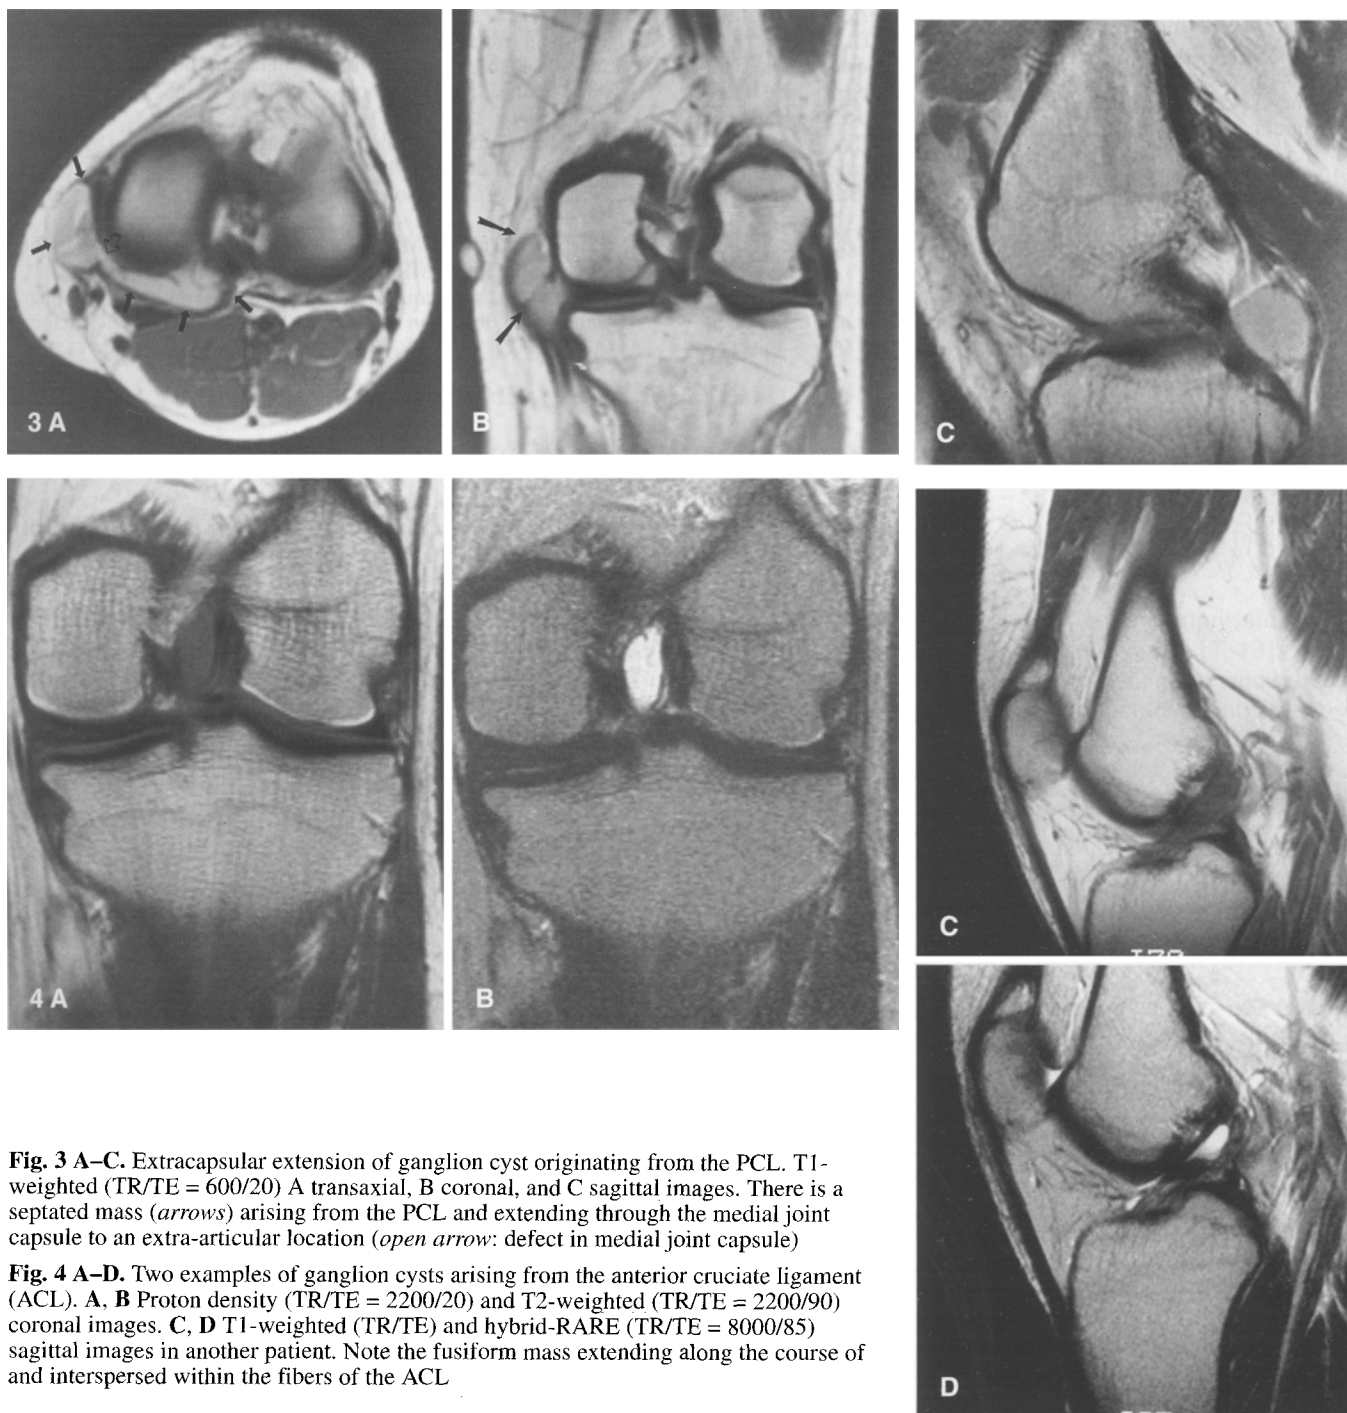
A-C. Extracapsular extension of ganglion cyst originating from the PCL. T1-weighted (TR/TE = 600/20) A transaxial, B coronal, and C sagittal images. There is a septated mass (arrows) arising from the PCL and extending through the medial joint capsule to an extra-articular location (open arrow: defect in medial joint capsule)
